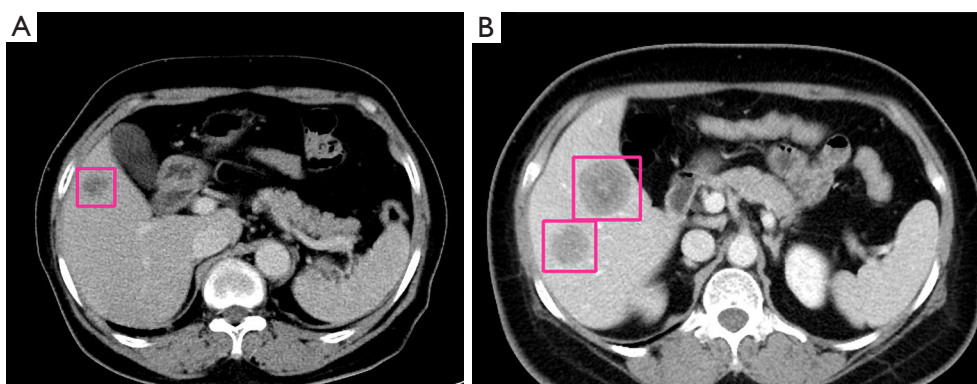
Rectangular boxes are used to mark regions of interest on contrast-enhanced computed tomography images in the portal venous phase. (A) Image from a 35-year-old woman with HER2-positive liver metastases. (B) Image from a 43-year-old woman with HER2-negative liver metastases. HER2, human epidermal growth factor receptor 2.
